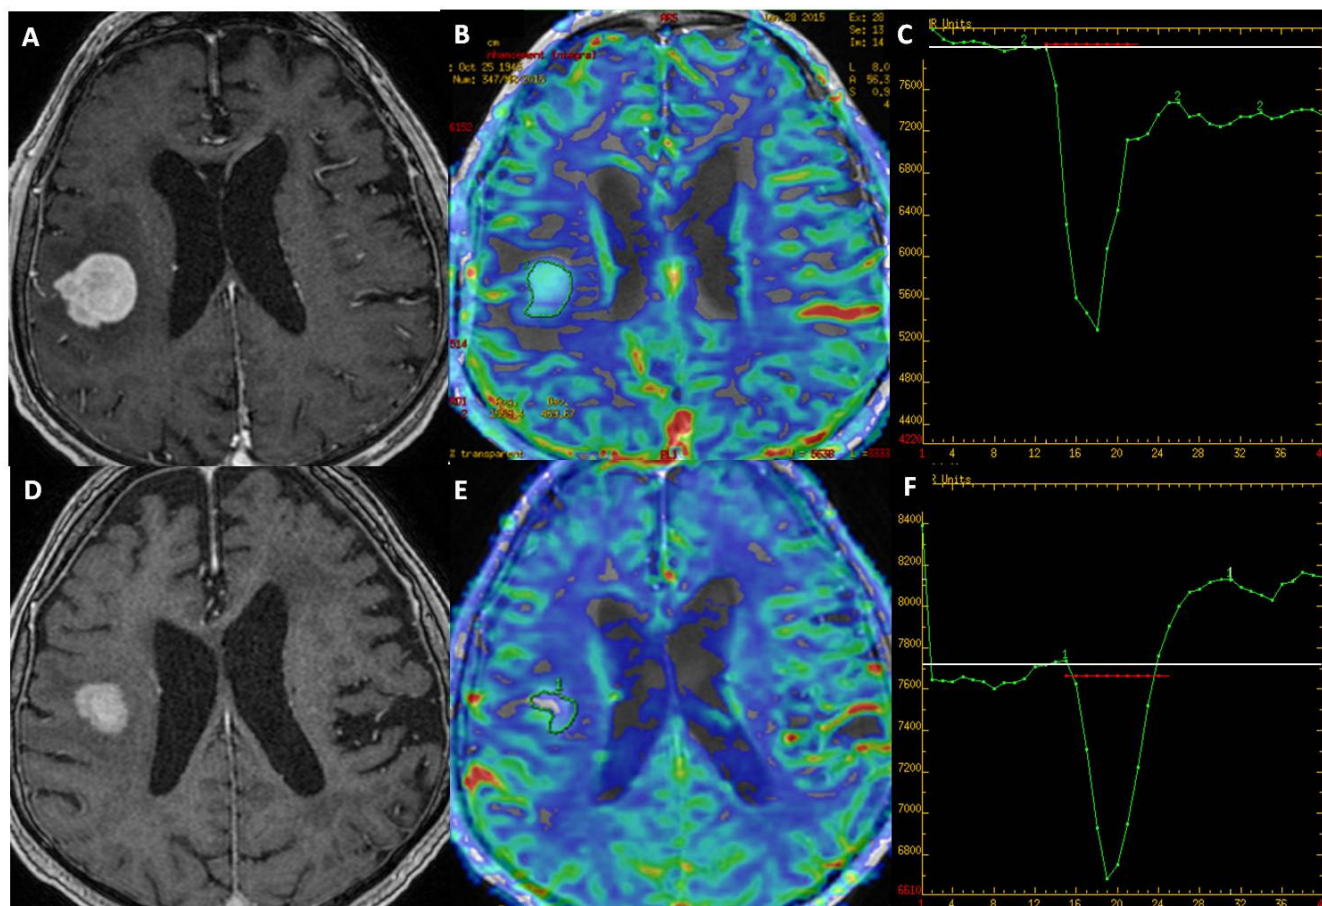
A patient with a single CNSL lesion in the right parietal lobe examined with 2 DSC perfusion techniques with (A–C) and without (D–F) a preloading bolus. Axial T1-weighted MR images (A, D) after contrast administration, showing strong enhancement. The CBV perfusion map with a preload (B) shows hyperperfusion compared to hypoperfusion seen on the CBV map without a preload (E). The perfusion curve after a preload (C) exceeds the baseline compared to the perfusion curve without a preload, which does not reach the baseline (F). CBV – cerebral blood volume; CNSL – central nervous system lymphoma; DSC – dynamic susceptibility contrast; MR – magnetic resonance.
